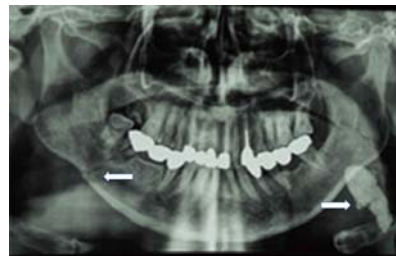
Orthopantomography showing a large radiopaque mass (arrow) in the left submandibular region, and bone fracture (arrow) in the right mandible.
